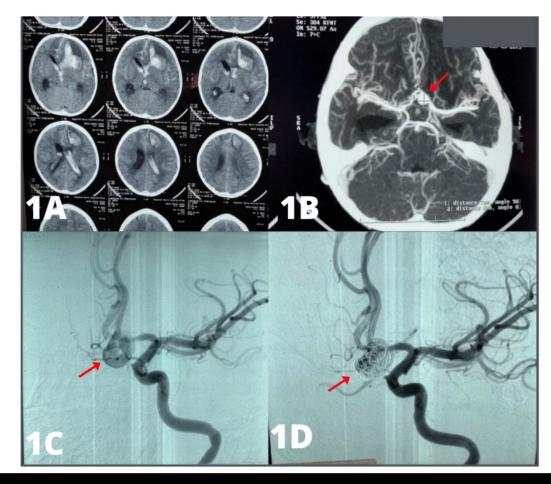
A. NCCT shows Fisher IV subarachnoid haemorrhage with a left frontal lobar intraparenchymal hematoma and acute hydrocephalus. B. CTA shows a giant aneurysm in the anterior communicating artery. C. Digital subtracted angiography shows a giant aneurysm in the anterior communicating artery and D. shows the aneurysm prior the embolization with coils.
